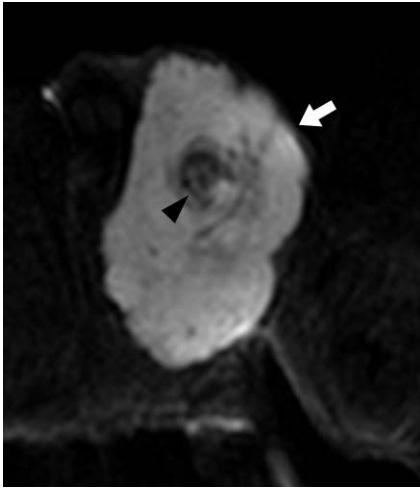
US and MR images of the huge scrotal mass. Color Doppler US image (a) demonstrates a huge heterogeneously hypoechoic and hypervascular mass (white arrows) encasing the left testis (black arrows) and epididymis. The coronal T1-weighted MR image (b) and the sagittal T2-weighted MR image (c) demonstrates relatively heterogeneous signal intensity soft tissue mass (white arrows) encasing the left testis (black arrow), epididymis, and spermatic cord. Internal vascular and ductal structures show no definite luminal narrowing or occlusion (black arrowheads in b-f). The sagittal contrast-enhanced T1-weighted MR image (d) shows a slightly heterogeneously enhancing soft tissue mass (white arrow) with a small necrotic portion. The axial diffusion-weighted image (e) with a high b value (1000 s/mm<sup>2</sup>) shows a high signal-intensity mass (white arrow) in the left scrotum.
